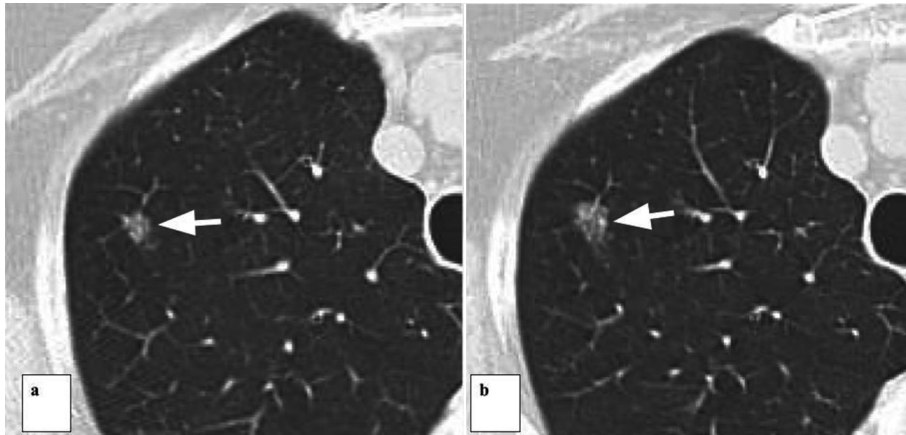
CT with lung window (bone filter, high resolution): patient with subsolid nodule categorized as Lung RADS 2, with annual follow-ups. (a) shows the nodule of the tomographic study of 2014 (arrow). (b) shows the 2018 study. Certain growth of the lesion could be observed (arrow), so it was decided to perform surgery.
